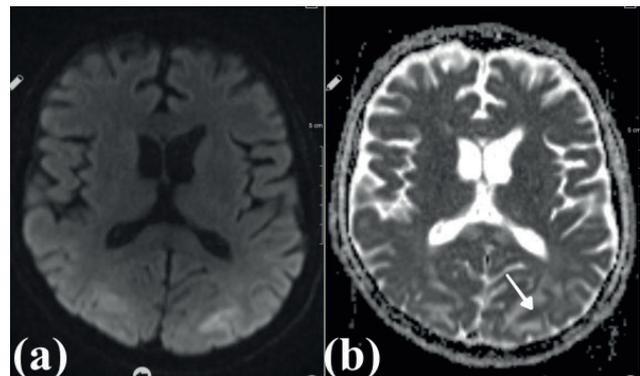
(a) Fifty-five-year-old man with end stage renal disease and severe hypertension. Axial DWI images with ADC inserts show foci of diffusion restriction within left parietal cortex. (b) ADC maps confirm diffusion restriction (White arrow)
